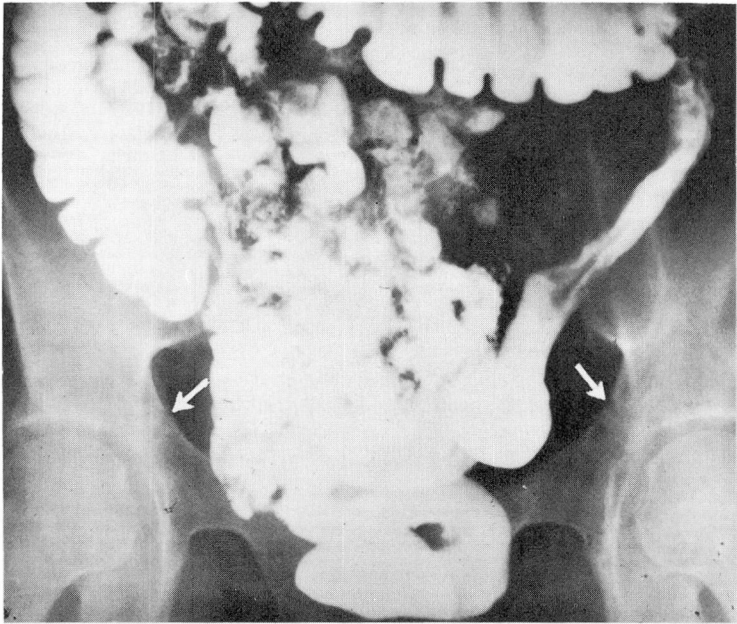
Roentgenogram showing evidence of bilateral pseudofractures (arrows) at the junctions of the pubic and ischial bodies. The pseudofractures appear as small radiolucent notches in the cortex.
